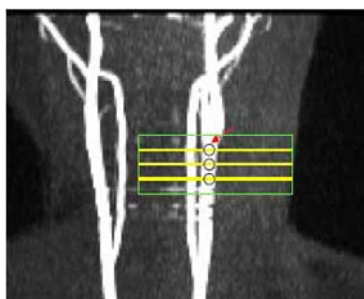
Slice locations for DENSE MRI scans. Red arrow indicates the bifurcation of the carotid arteries.
